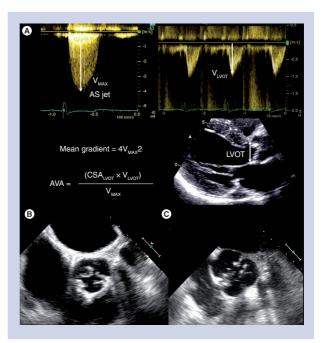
Assessment of the severity of aortic stenosis and aortic valve anatomy. Calculation of mean pressure gradient requires the V_{MAX} of AS jet obtained from continuous-wave Doppler, using the Bernoulli equation (A). Using the continuity equation, AVA is calculated. The LVOT diameter is measured and the CSA_{LVOT} is calculated. In addition, the V_{LVOT} is obtained from pulsed-wave Doppler in the apical long-axis view and the V_{MAX} jet is measured from the continuous wave Doppler recordings through the aortic valve. Either the velocity time integrals or velocities can be applied in the equation for the calculation of AVA. Transesophageal echocardiography permits direct visualization of the aortic valve: tricuspid (B) or bicuspid (C). AS jet: Aortic jet; AVA: Aortic valve area; CSA: Cross-sectional area;
